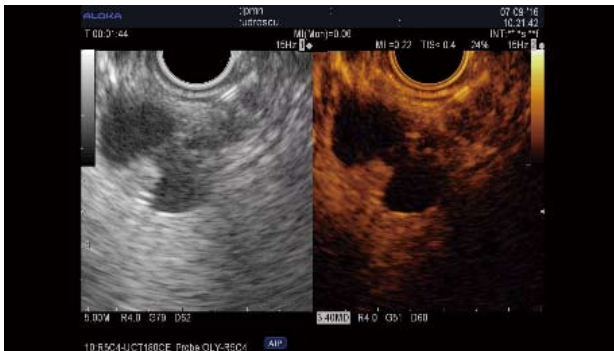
CH-endoscopic ultrasound-fine needle aspiration of a vascularized mural nodules within mucinous cystadenoma. An endoscopic ultrasound-fine needle aspiration needle during the puncture of one of the mural nodules is better seen on the contrast image (right).
